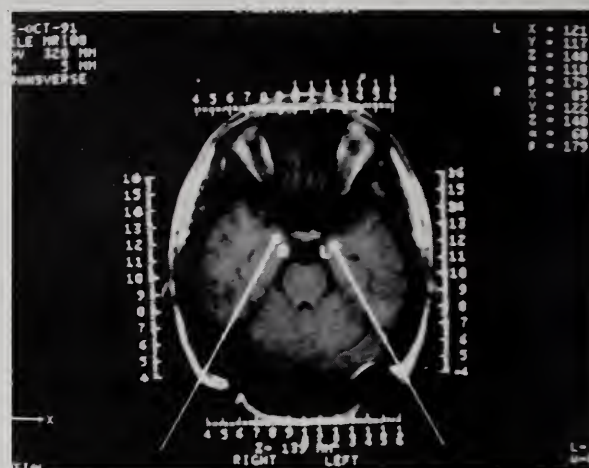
Magnetic resonance imaging (MRI) with superimposed stereotactic coordinate grid. Planned pathways of two medial temporal depth electrodes are shown. The target coordinates of the tips of the depth electrodes are shown at right of image.
